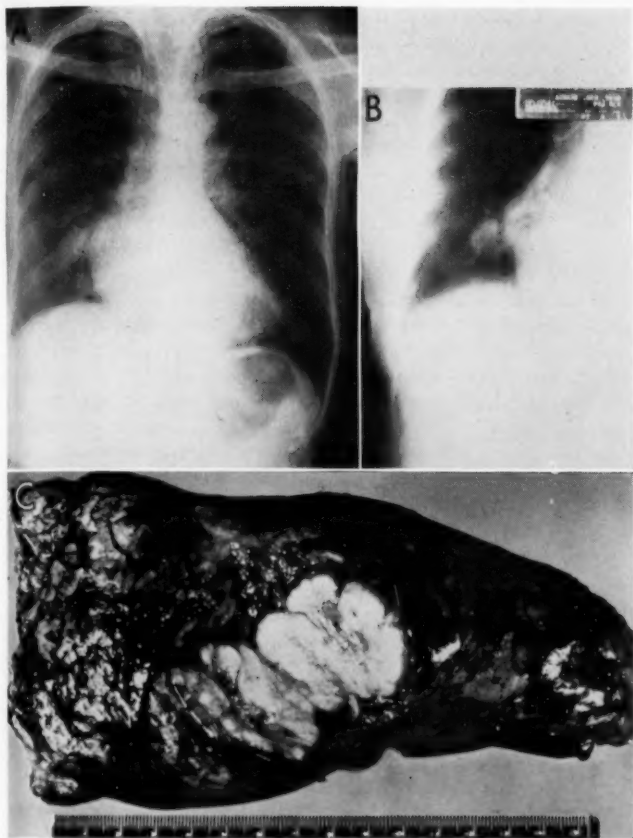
Routine chest roentgenograms (A and B) of a woman, aged 70, showing a 3.5-cm. nodule in the right lower lobe. Note the absence of the left breast, which had been removed 5 years earlier for carcinoma. Right lower lobectomy (C) demonstrated a primary bronchiolar carcinoma. The patient is apparently well 3 years later.
